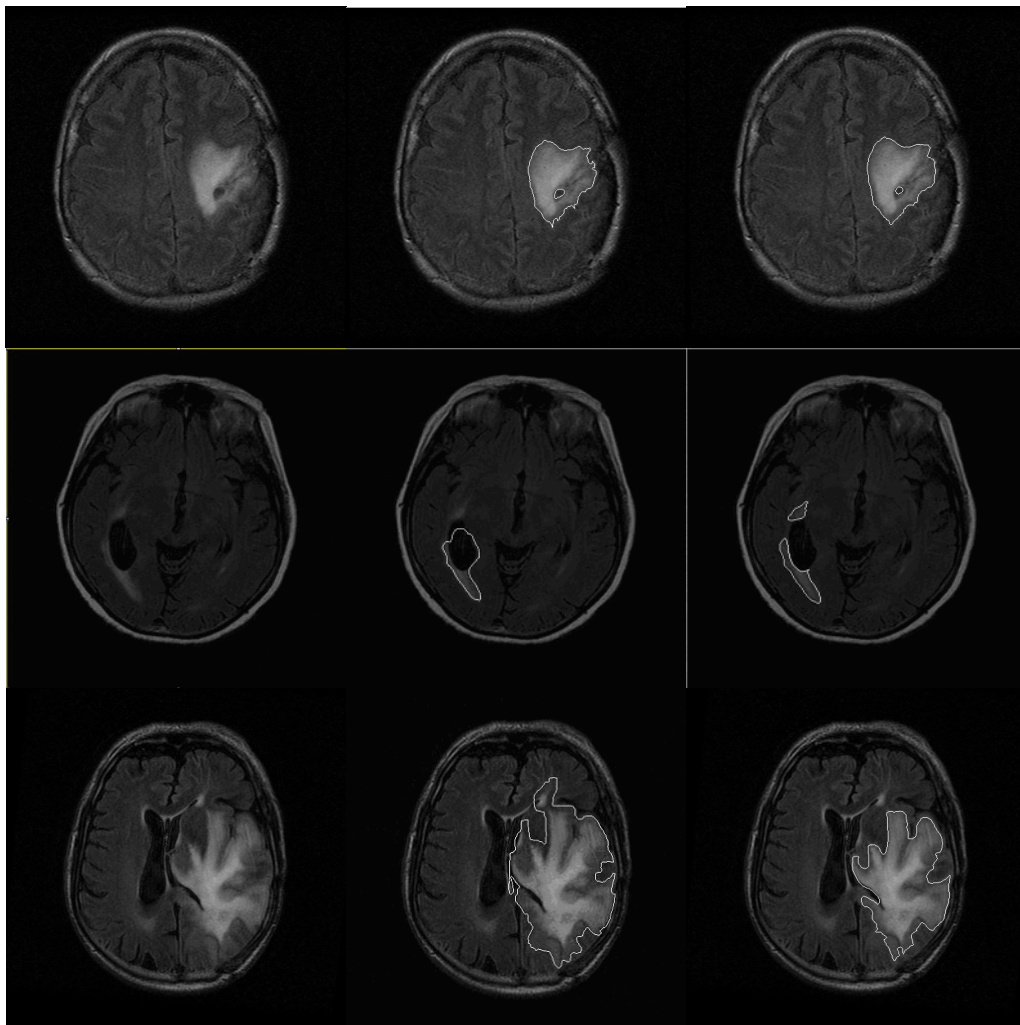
Examples of adaptive training for Patient 1 to Patient 3 (FLAIR images)
